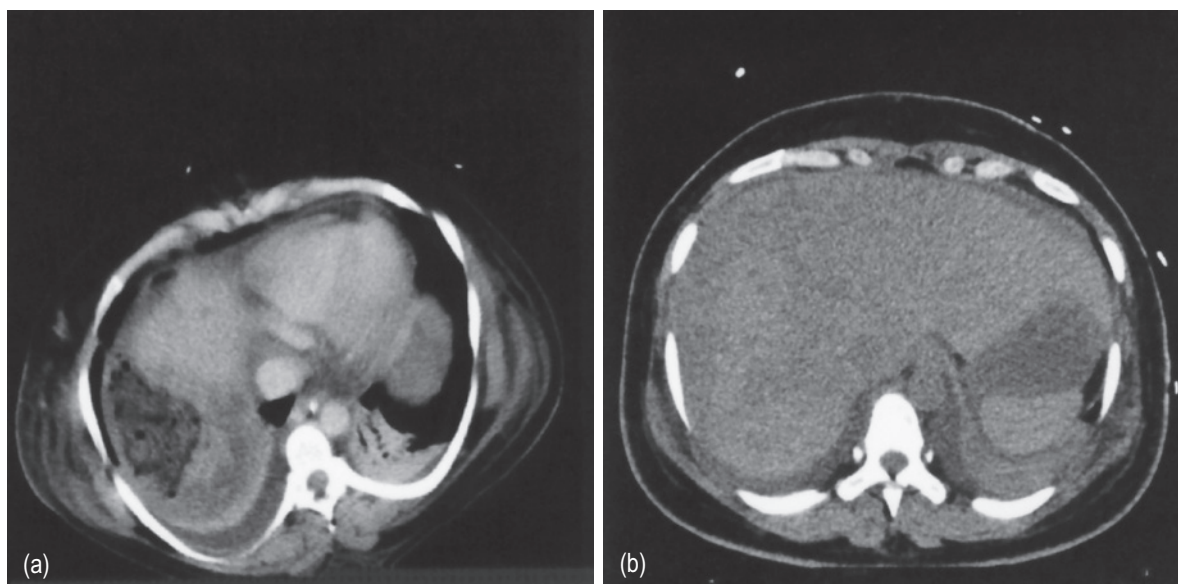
Liver computed tomography in pregnancy-related liver disease demonstrating abnormal perfusion (a and b) with rupture, packing (a) and associated areas of infarction. Major bleeding into the liver.
